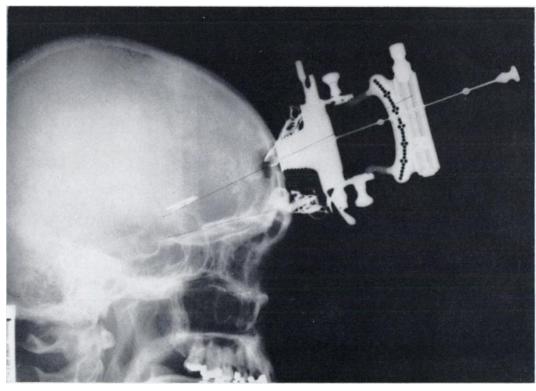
Stereotactic device *in situ*. One set of seeds has already been inserted. The distance between the two spheres on the aiming needle corresponds to the distance between the lower sphere and the centre of rotation of the instrument. The site of the target area is marked on the radiograph and a line projected from this point through the centre of rotation to cross the perforated scale will indicate the site of the target in this plane.
